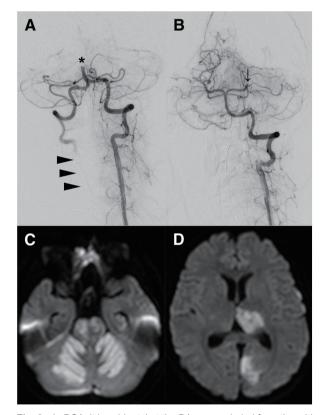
In DSA, it is evident that the BA was occluded from the mid BA (asterisk), and the right VA flowed retrogradely via the union from the left VA (arrowheads). (A) Recanalization of the BA with thrombolysis in cerebral infarction grade 2b was achieved by MT. The P2 segment of the left posterior cerebral artery was remained to be occluded (arrow). (B) MRI on the next day of MT showed infarction in the territories of the bilateral superior cereblar artery, perforators of BA, and left posterior cerebral artery (C and D). BA: basilar artery; MT: mechanical thrombectomy; VA: vertebral artery
